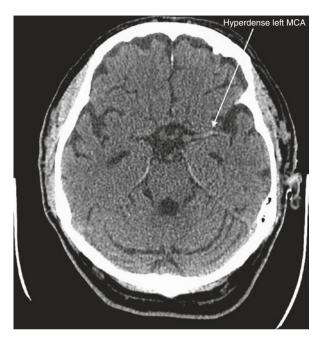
Head CT with hyperdense left MCA sign
